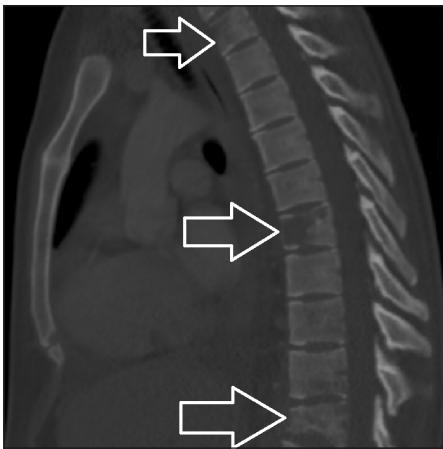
Computed tomographic image (sagittal section) of the chest showing a destructive lesion (open arrow) occupying a large part of the T8 vertebra and to a lesser extent T3.
